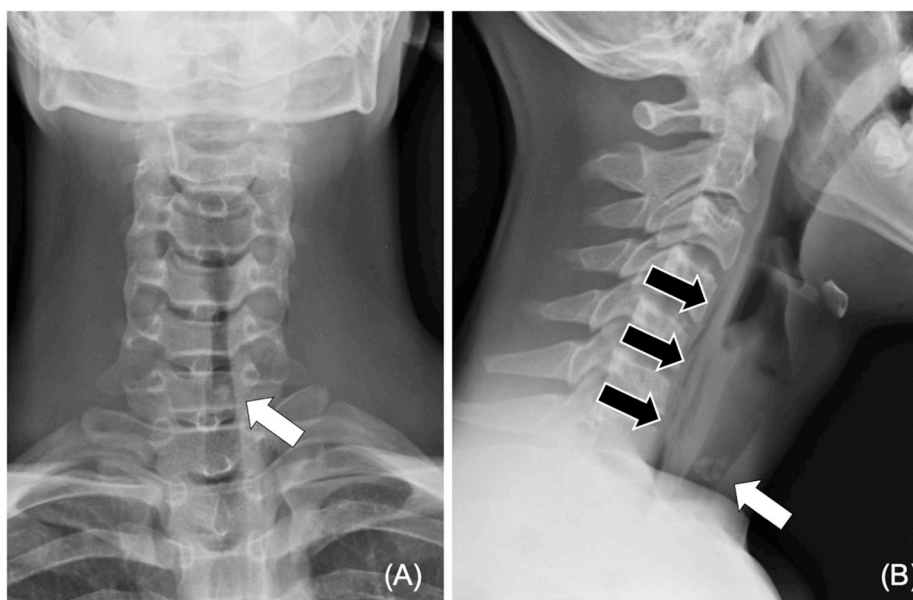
Soft-tissue neck X-ray.
